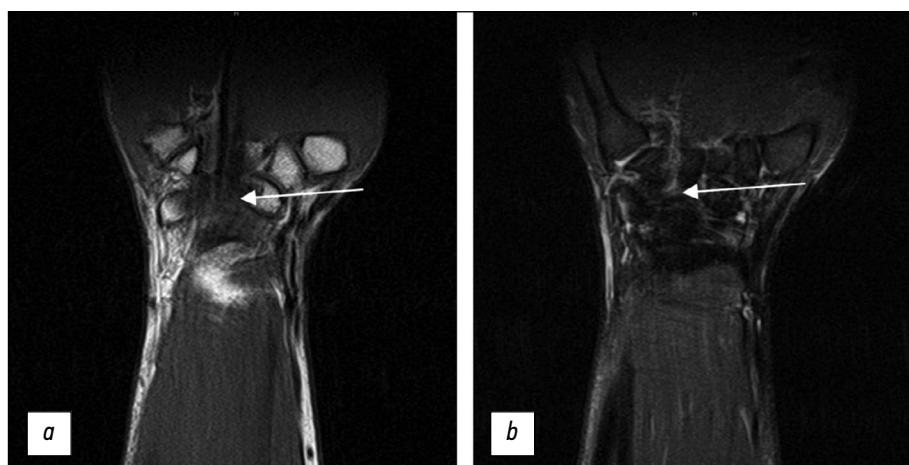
Reduced imaging quality because of movement artifacts without using a splint (arrows); (a) T1-weighted images in the coronal plane; (b) STIR protocol in the coronal plane.
